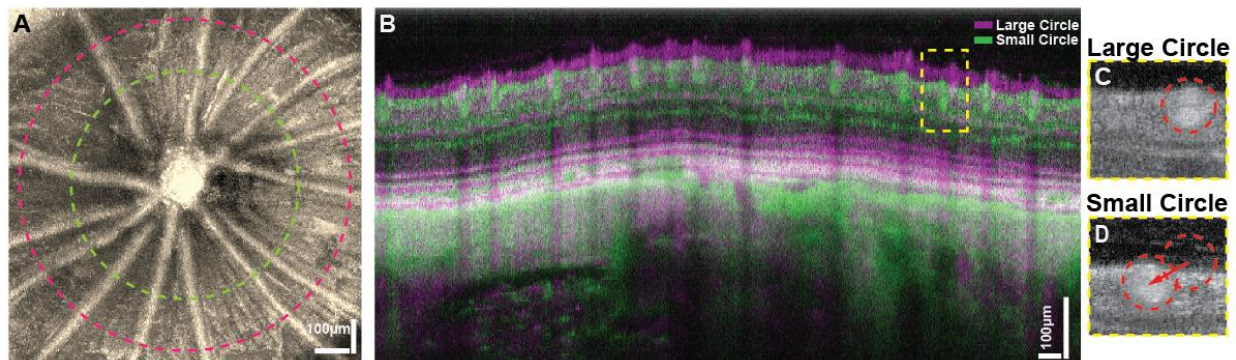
Total blood flow analysis. (A) *En-face* image of the ONH with violet and green dashed lines marking the double circle Doppler OCT scanning pattern. (B) Overlay of 2 representative concentric circular OCT scans. (C) and (D) present magnified views of the area in (B) marked with the yellow dashed line, from the large and small diameter circular scans respectively.
